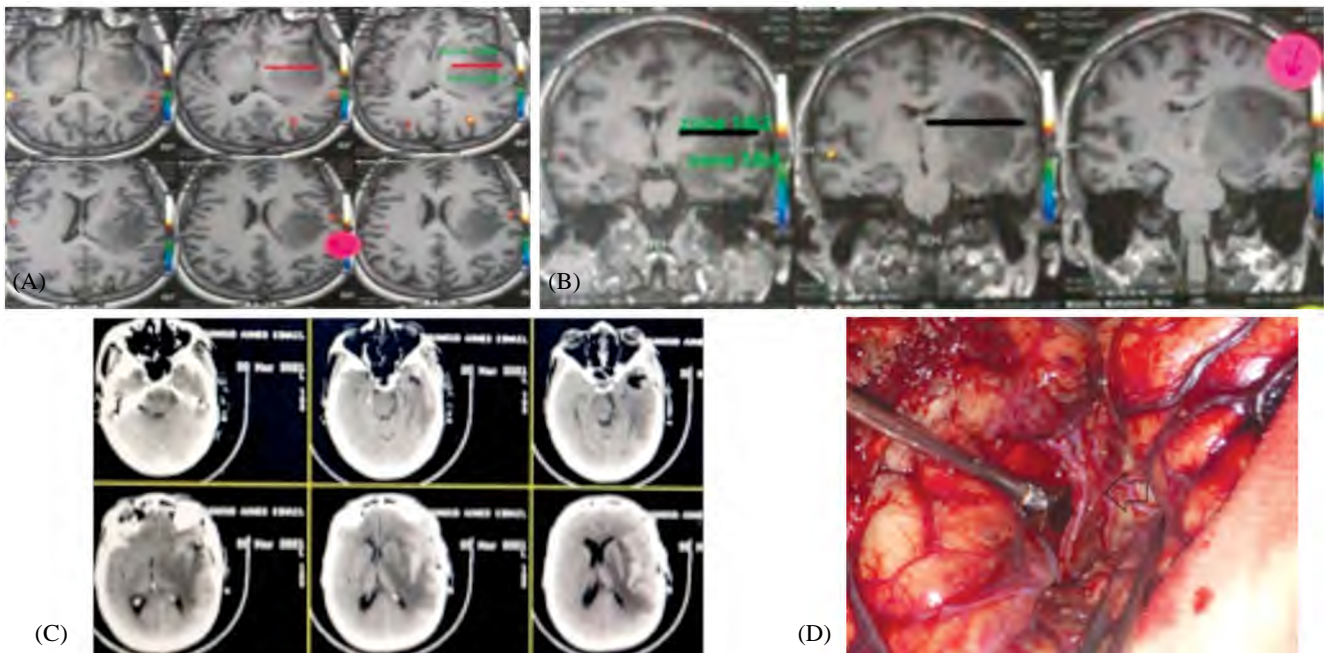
Case 2 presentation, axial (a) and Coronal (b) Preoperative MRI showing zone classification in relation to tumor. Postoperative CT brain with good resection of tumor (c). (d) Showing intraoperative photo and hallow arrow refer to skeletonized MCA branches after successful sylvian fissure dissection.
